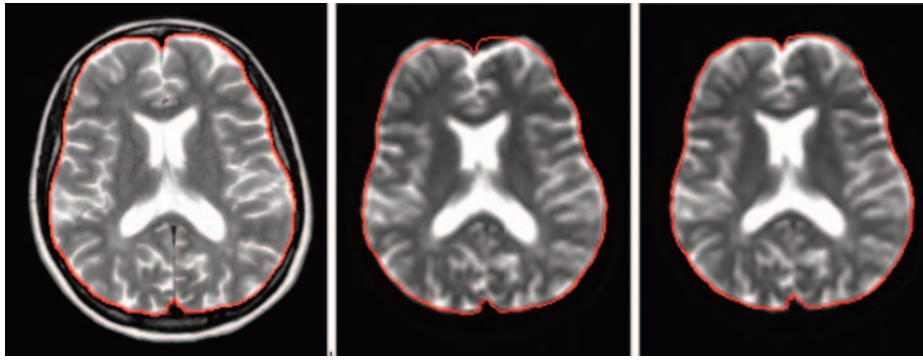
Geometric distortions inherent in echo-planar imaging (EPI), evident from the comparison between a fast spin-echo (FSE) T2-weighted image (*left*) and the $b = 0$ image of a pulsed gradient SE-EPI experiment, after rigid (*middle*) and nonlinear transformation (*right*)⁶⁰ to match the anatomy of the FSE T2-weighted image. The cranial contents are outlined in red on the FSE image, and the same outline is superimposed on the other images to show the degree of distortion.
